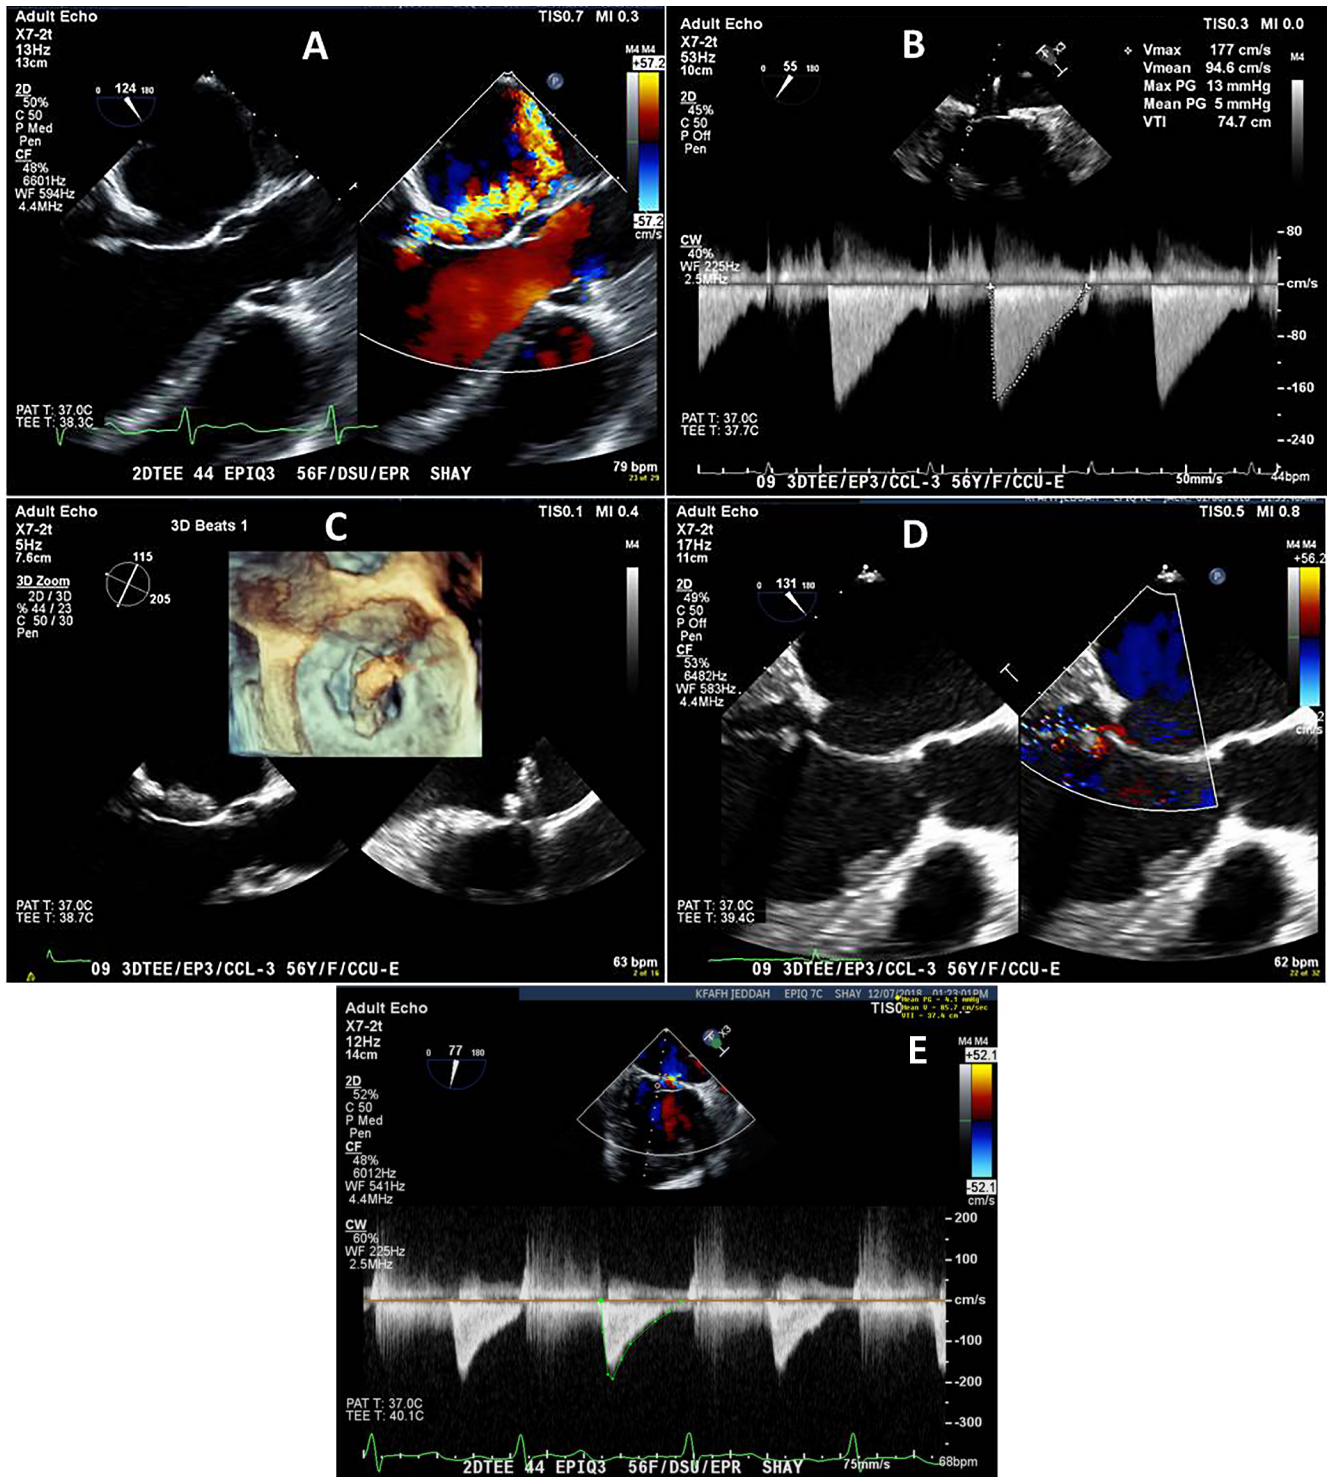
Panel A. 4-chamber Transesophageal Echocardiographic Image with color Doppler showing eccentric direction of severe mitral regurgitation. Panel B. Continuous wave-Doppler of mitral inflow showed pressure gradient across the valve before procedure. Panel C. Enface visualization of mitral clip by 3D transesophageal echocardiography to check perpendicularity before implantation. Panel D. 4- chamber Transesophageal Echocardiographic Image with color Doppler immediately post-procedure. Panel E. Continuous wave-Doppler of mitral inflow showed pressure gradient across the valve post procedure.
